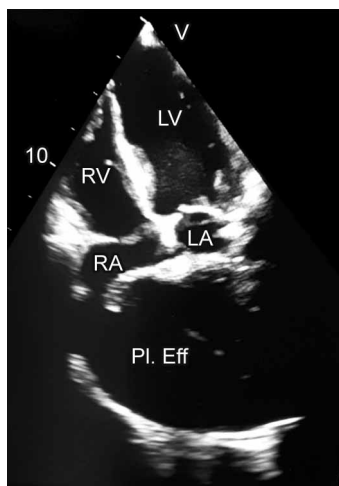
Transthoracic echocardiographic image showing apical 4-chamber view with large pleural effusion compressing the atria. RA, right atrium; RV, right ventricle; LA, left atrium; LV, left ventricle; PI Eff, pleural effusion
